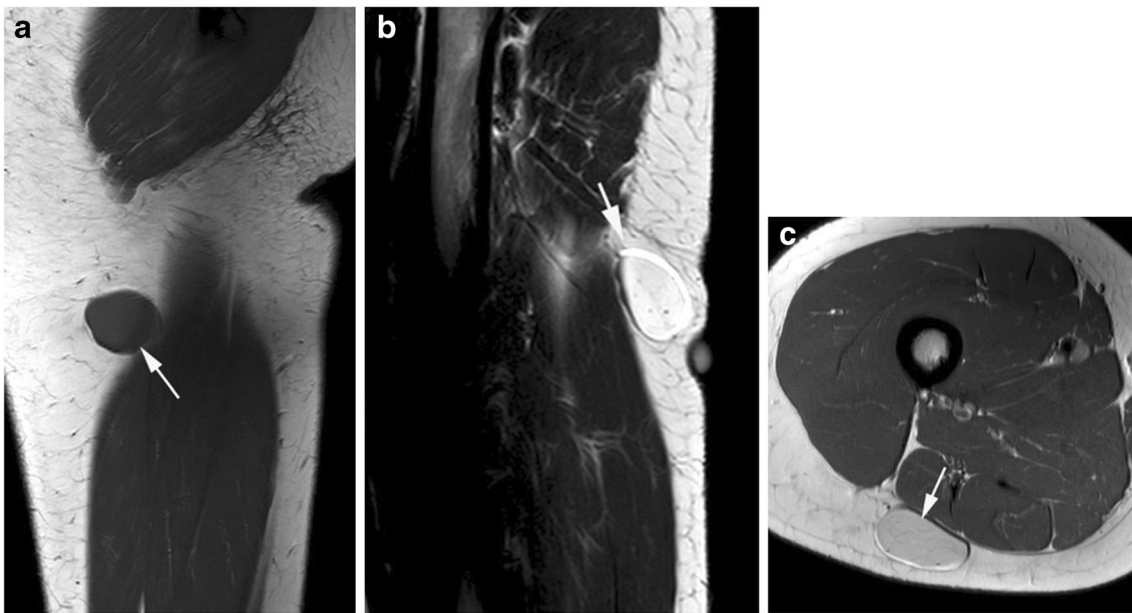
A 26-year-old female presenting with a small mass in the posterior aspect of the right thigh. a Coronal T1W TSE, b sagittal T2W FSE, and c axial PDW FSE MR images show a small well-defined superficial mass
